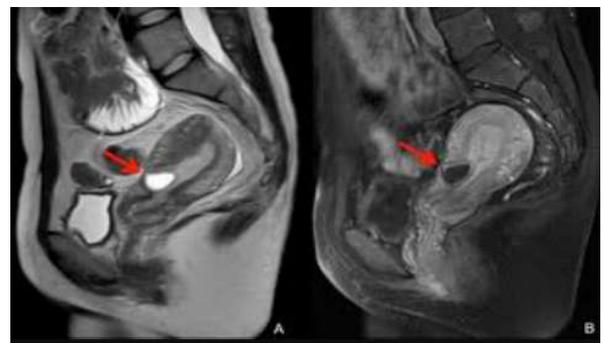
5&6 MRI picture showing caesarean scar pregnancy with extension into the myometrium upto the serosa without a overlying myometrial tissue
